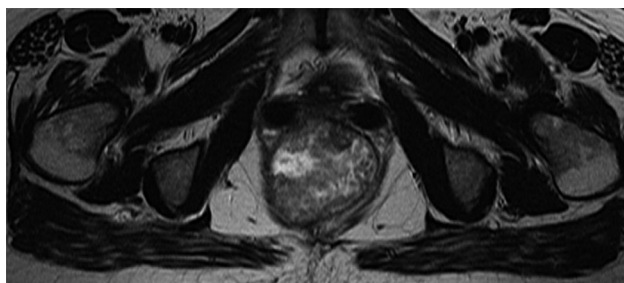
MRI of the lower abdomen showing the rectal carcinoma with invasion of the cervix and uterus.
